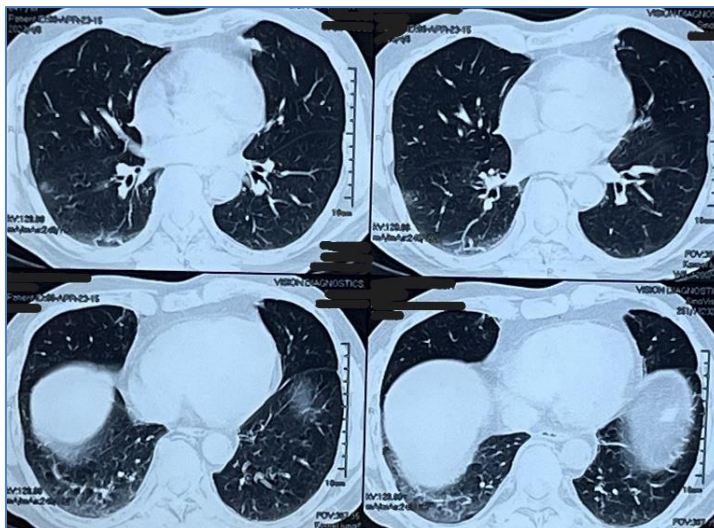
HRCT Thorax showing minimal right lower lobe infiltrates without any lung parenchymal abnormality
